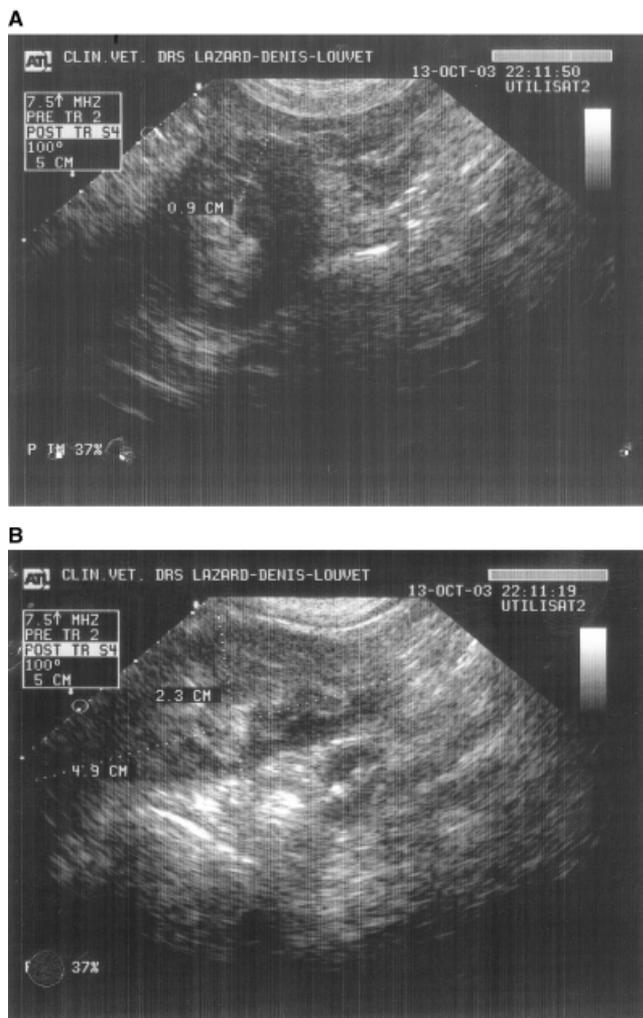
Transverse and sagittal sonograms of the intestinal mass. Notice the marked (9 mm), circumferential, irregular hypoechoic thickening with loss of bowel layering (A). (B) Sagittal image of the 4.9-cm mass that is grossly hypoechoic with central linear hyperechogenicities.
